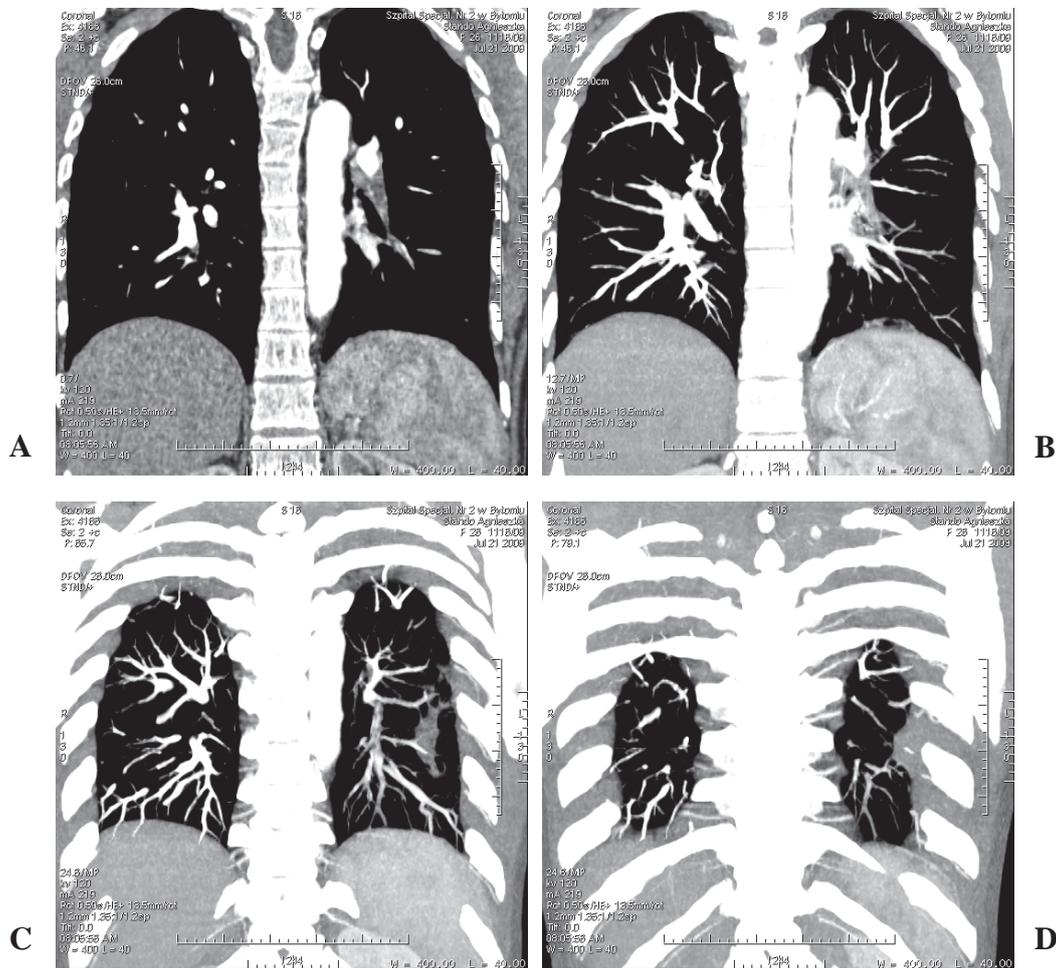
Angio-CT of pulmonary arteries: visible normal pulmonary trunk and right pulmonary artery with branching – on left side mural thrombus in branching of left pulmonary artery and 6th segmental artery, parenchymal mural condensation in lung and post-inflammatory lesion in costophrenic angle.
